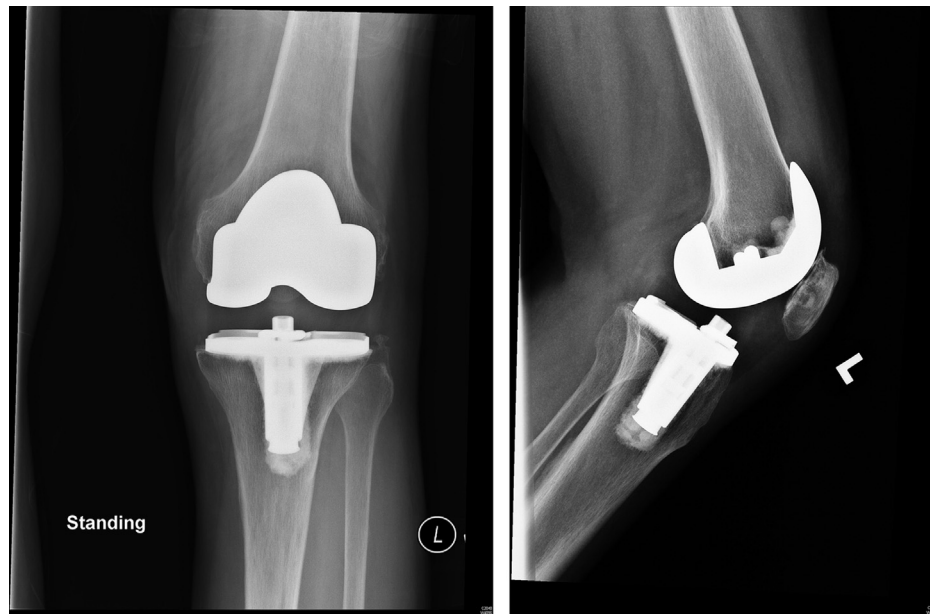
Postoperative radiographs of Case 3.
